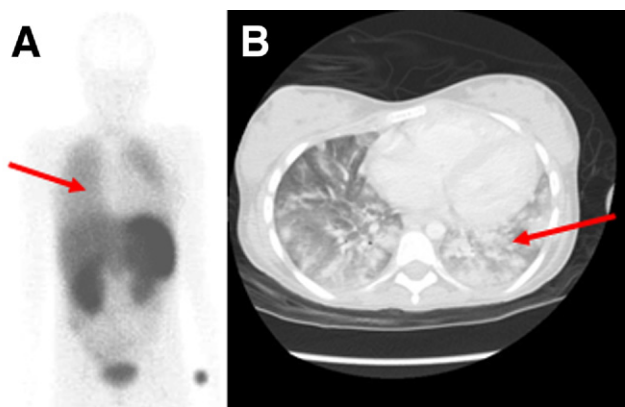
^{111}In -Octreoscan (A) and axial CT lung window images (B). Unusual lung uptake of ^{111}In activity due to diffuse inflammatory processes (pulmonary interstitial fibrosis). (Color version of figure is available online.)
